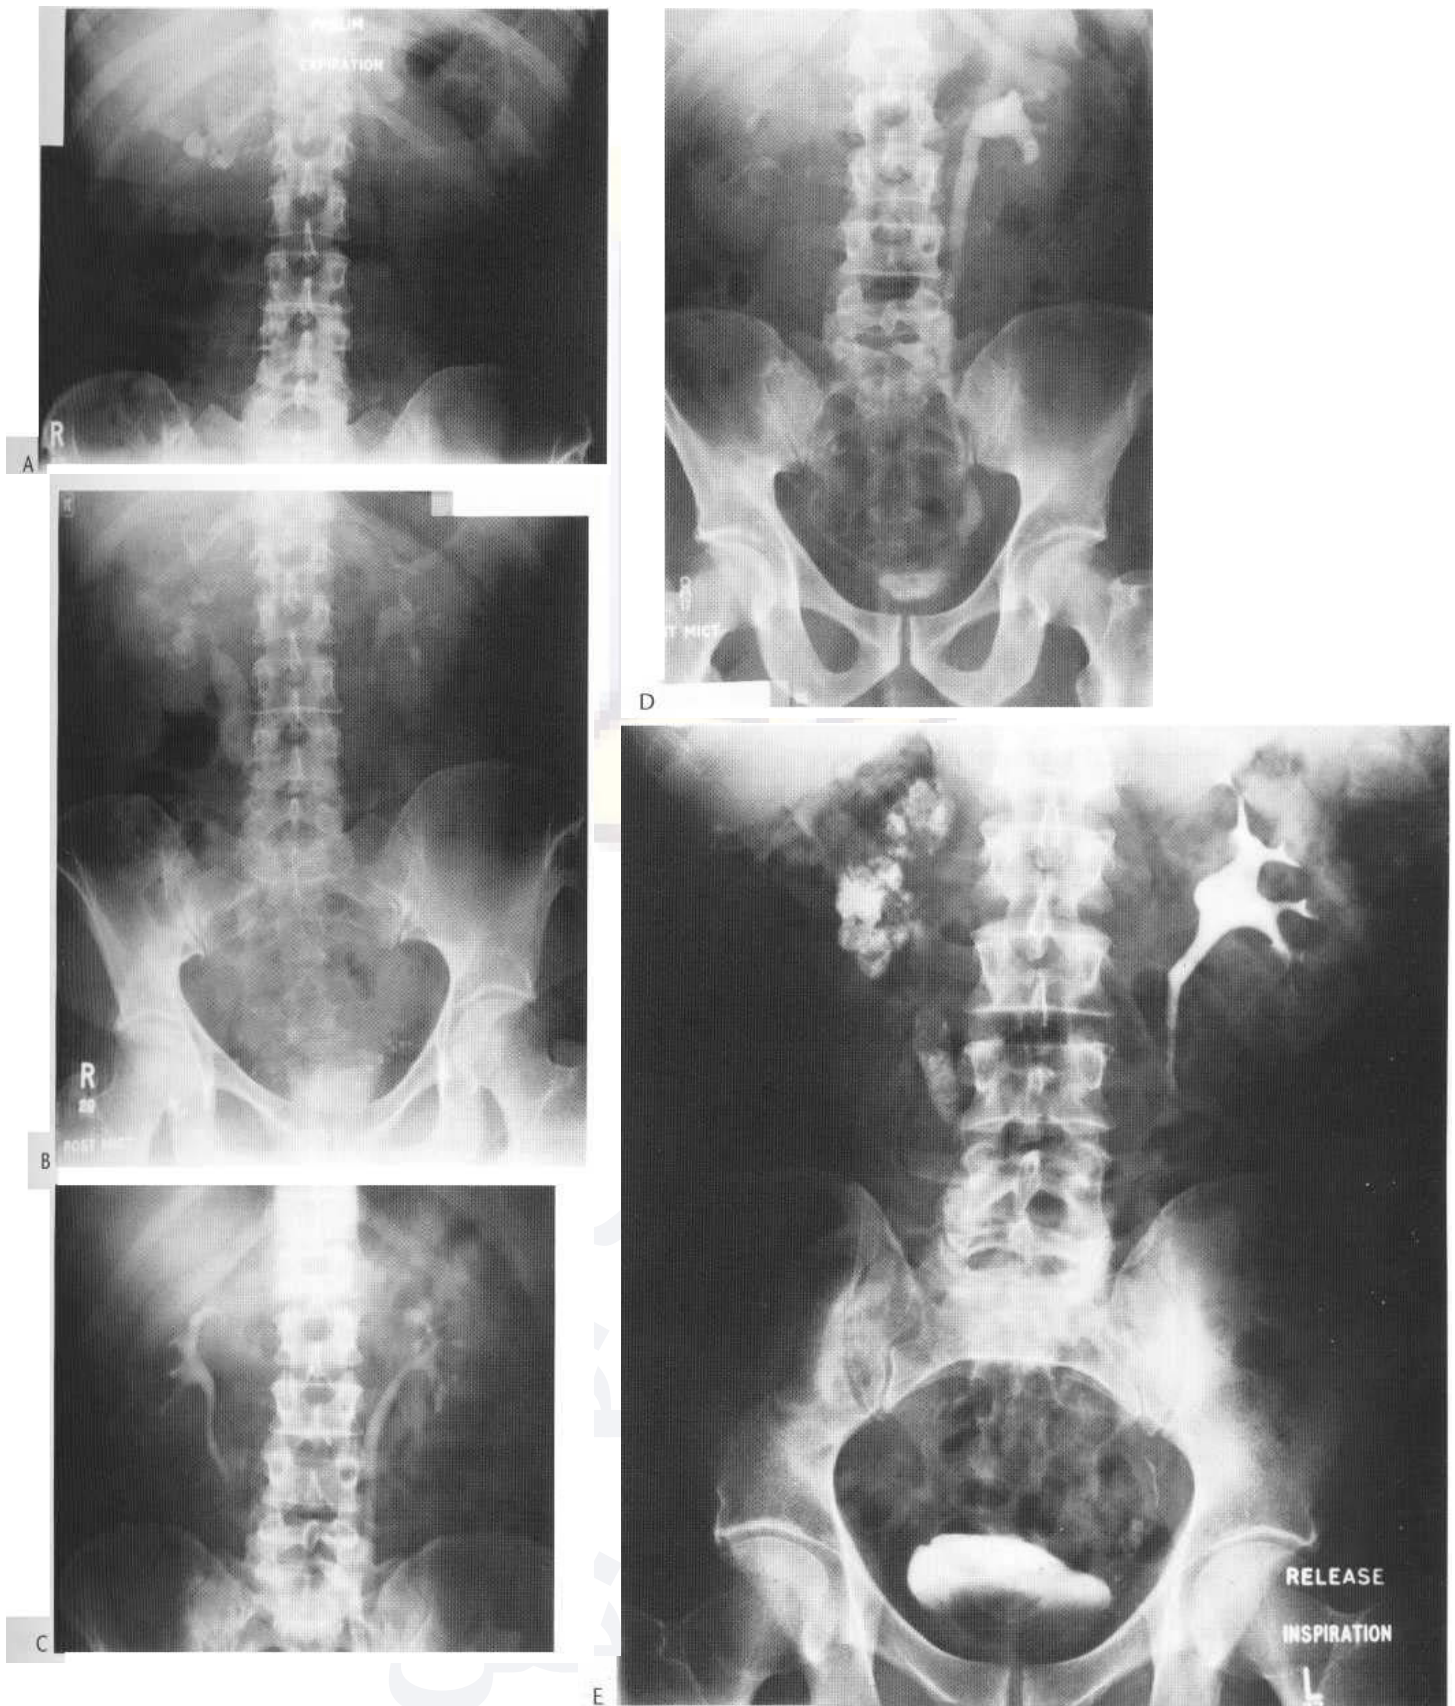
Urinary tract tuberculosis. The plain film (A) demonstrates calcification within distended upper pole calyces. The IVU (B) shows strictures at the calyceal necks with hydrocalyces and fibrous stricturing of the renal pelvis and the ureter. The tomogram from an IVU on another patient (C) shows a stricture at the neck of the upper pole calyx. This progresses on treatment and the full length film from the IVU performed 6 months later shows the upper pole calyx has been completely amputated (D). Distal ureteric strictures are also present. Classical end-stage upper tract tuberculosis is the auto-nephrectomy (E) in which the chronically obstructed pelvicalyceal system is filled with calcifying caseous pus associated with complete renal parenchymal destruction. In this case there is also similar calcifying pus in an obstructed dilated upper ureter.
